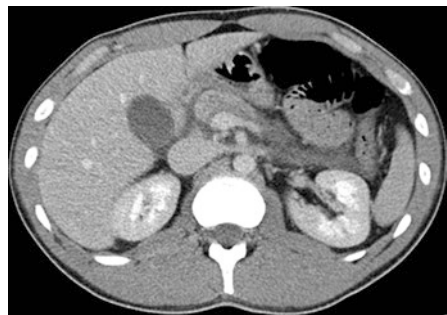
Grade II pancreatic injury. CT shows a linear laceration across the distal body of the pancreas without ductal injury. There is also peripancreatic fluid and edema and laceration in the liver
